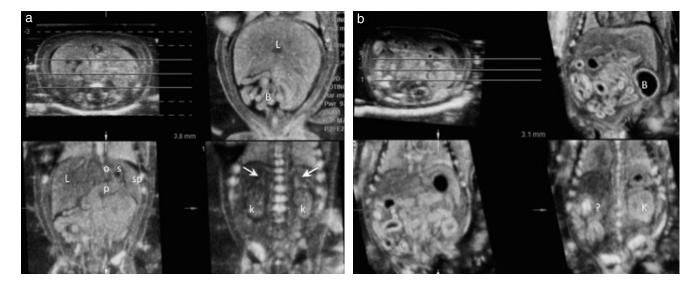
Postmortem ultrasound of fetal abdomen (tomographic ultrasound imaging of coronal plane). Images were obtained using a linear probe (RSP 6-16). (a) Normal abdomen in a 14-week fetus terminated for Down syndrome; visible are the normal liver (L), stomach (s), esophagus (o), pancreas (p), spleen (sp), bowel (B), kidneys (k) and adrenal glands (arrows). (b) A 14-week fetus terminated for multiple anomalies. Bowel dilatation (B) and one dysplastic kidney (K) are evident, with contralateral kidney agenesis (?).
